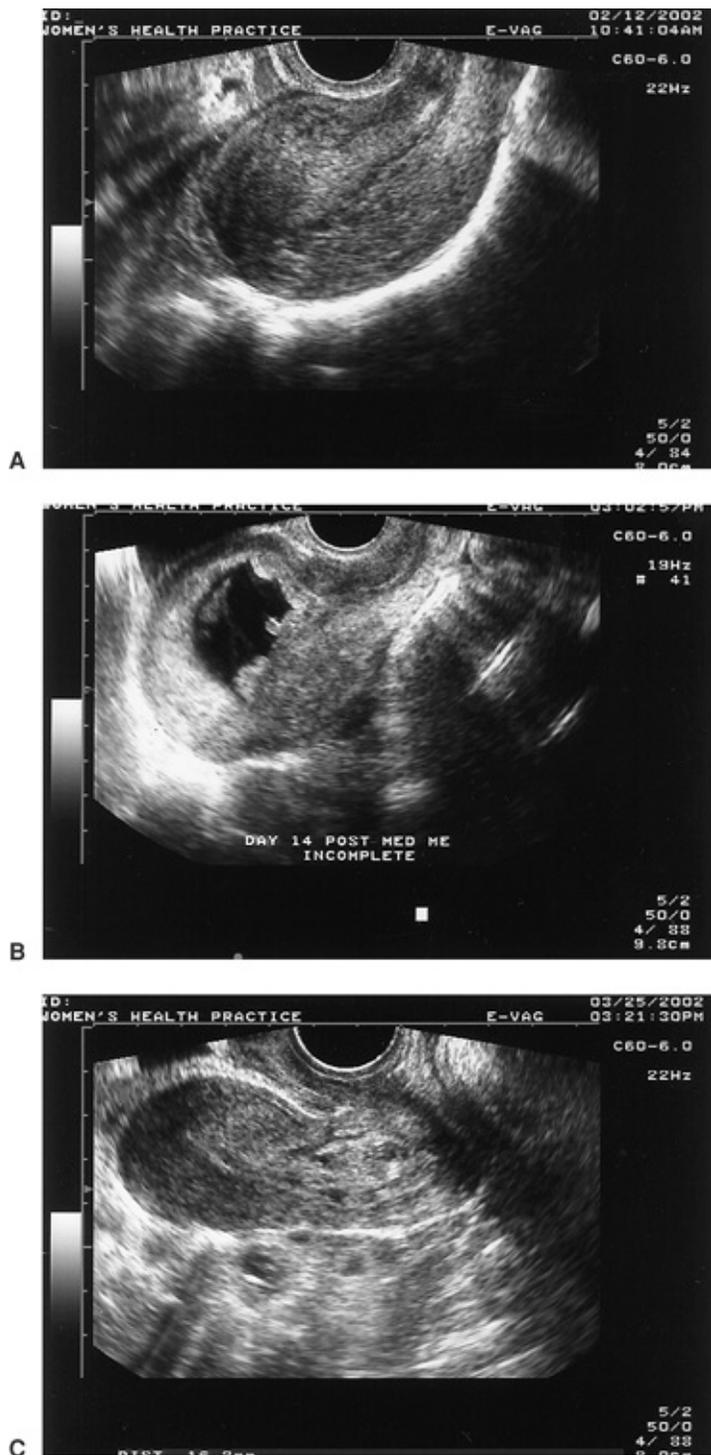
A: Transvaginal ultrasound of a 42-day pregnancy 4 hours after misoprostol ingestion. Heavy bleeding and passage of tissue indicated that the pregnancy termination had probably completed; the ultrasound confirms the absence of a gestational sac and that the medication abortion was effective. B: Day 14 after a medication abortion of a 47-day pregnancy. Transvaginal ultrasound shows retention of gestational sac, although no fetal development or fetal cardiac activity is seen. This is
